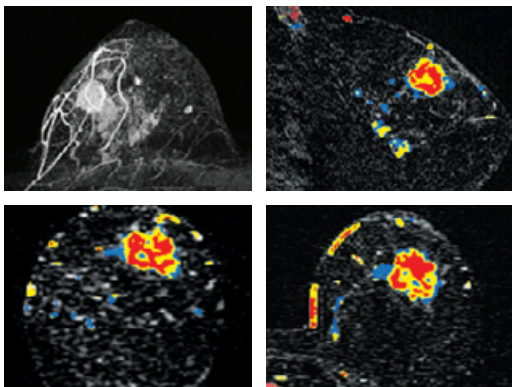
Breast MRI – an example of how cancer typically presents on MRI.
